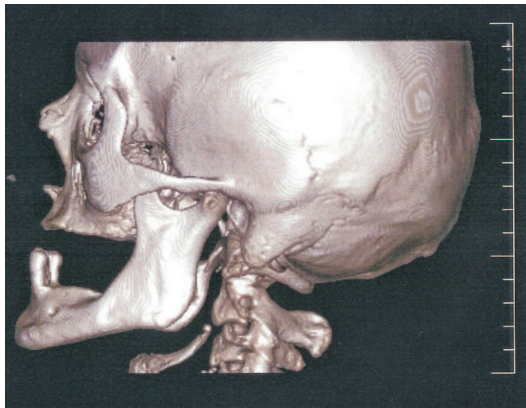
3D-CT analysis of the TMJ with destructive cysts: (a) the healthy TMJ and the left ramus mandibulae; (b) the destructive cyst in the right ramus mandibulae; (c)–(d) the multiple keratocysts of the TMJ situated in the bone-jaws.
